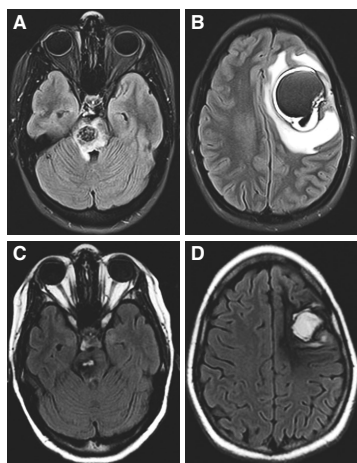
Vemurafenib for melanoma brain metastases. Brain MRI (A,B) before and (C,D) after six months of treatment with vemurafenib. Modified with permission from Rochet et al. 2011²³¹. Copyright Massachusetts Medical Society.
